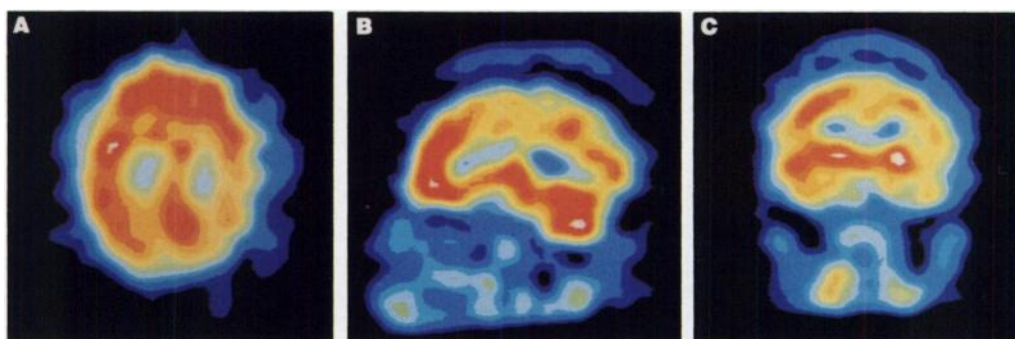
Technetium-99m-HMPAO SPECT transverse (A), sagittal (B) and coronal (C) sections before (9/15/95) the ECT treatment. All sections pass through the posterior frontal cortex.
